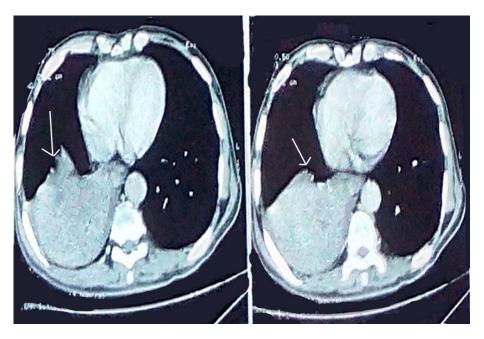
CT of chest with contrast in mediastinal view displaying 5 cm right perihilar soft tissue mass with surrounding collapse
